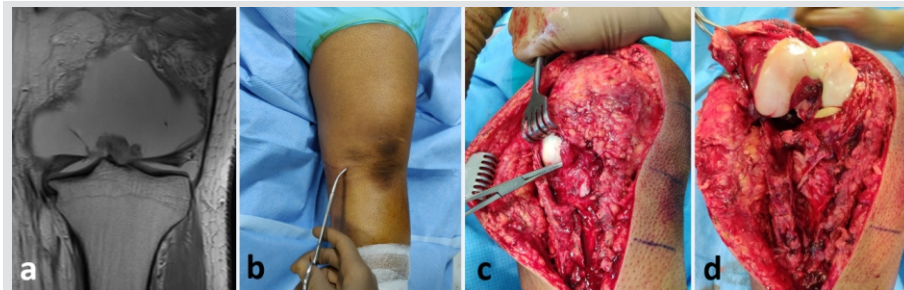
Stener type lesion. (a) MRI scan T2-weighted coronal image showing the distally torn MCL flipped into the joint. (b) Clinical picture of the same patient who did not have a congruent reduction due to the incarcerated tissue seen as a dimple on the medial side. (c) The torn tissue was found stuck between the medial femoral and tibial condyles. (d) Removal of the incarcerated MCL enabled reduction but gaping of the medial joint space is seen.
